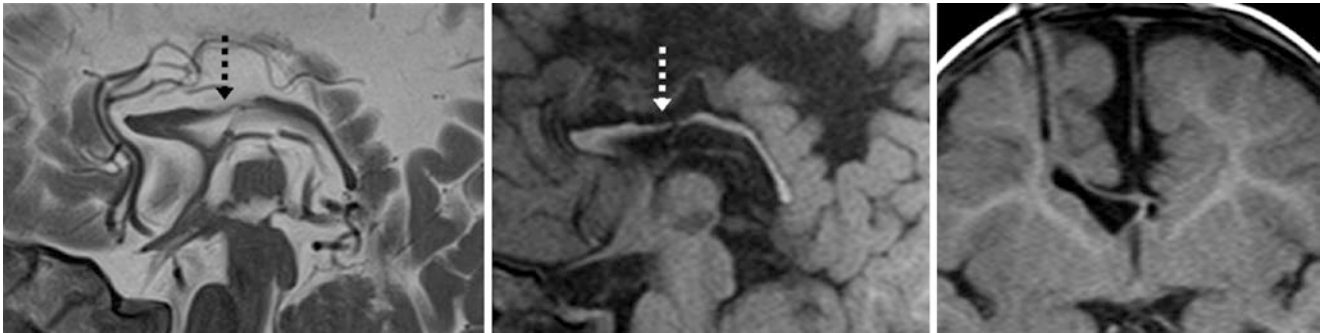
Comparison case of iatrogenic atrophy from shunting. An 11 month old had had a shunt catheter since birth. 3T MRI demonstrated severe thinning and focal atrophy of the callosal body (arrows) on sagittal T2WI (left) and T1WI (middle). On a coronal T1WI (right), note the catheter with enlarged frontal horn caused by instrument-related atrophy
